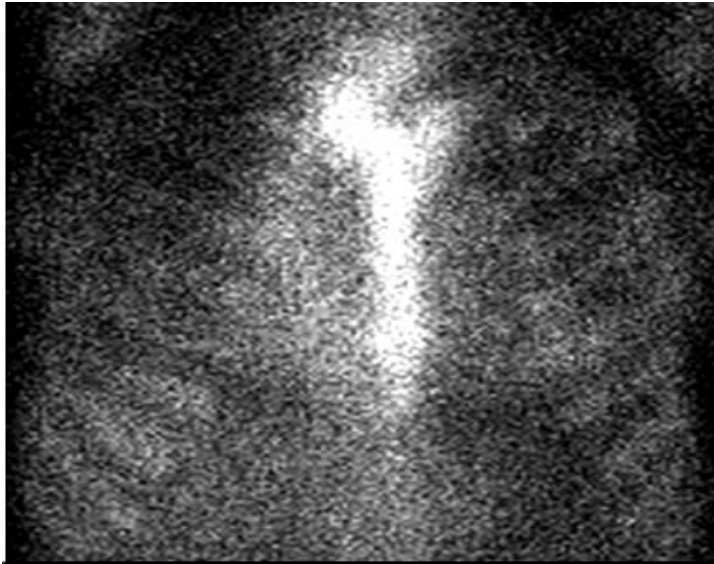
SPECT/CT: Technetium 99 and pyrophosphates with abnormal distribution of Perugini Grade 2 tracer.
